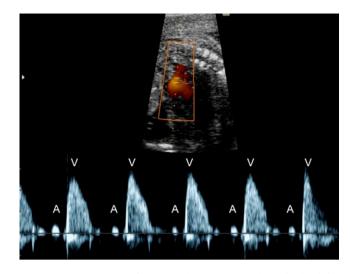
Example of a normal Doppler tracing obtained by simultaneous pulse wave Doppler of the aorta and the SVC. The Doppler sample volume is simultaneously placed within the aorta and the SVC.
